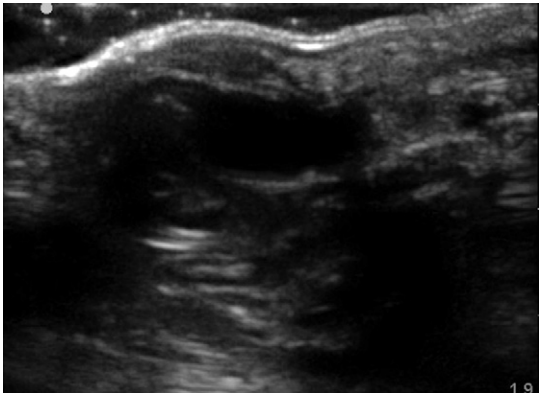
Sonographic image of the patient's palmar mass (13-6 MHz linear-array transducer).
